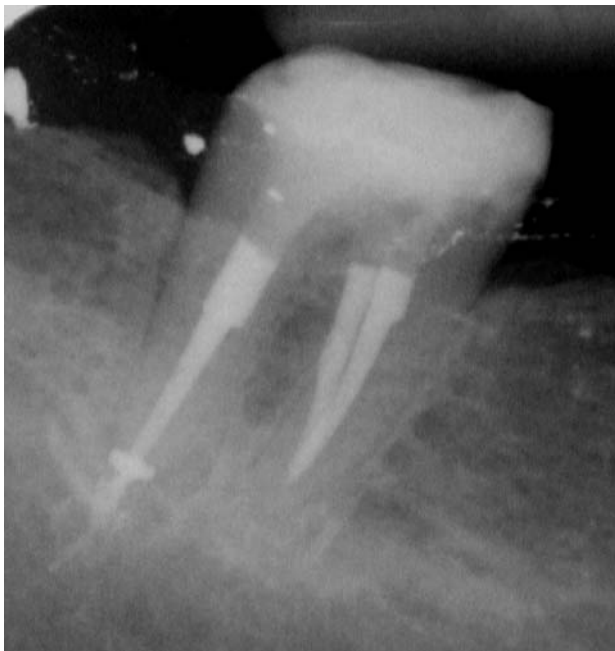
The radiograph showing the root canal obturation complimented by the adhesive build up procedure. The previous cylindrical post places are now hermetically filled up by the root canal obturation material. The distal root shows some apical extrusion, probably associated with a lack of an apical constriction.
